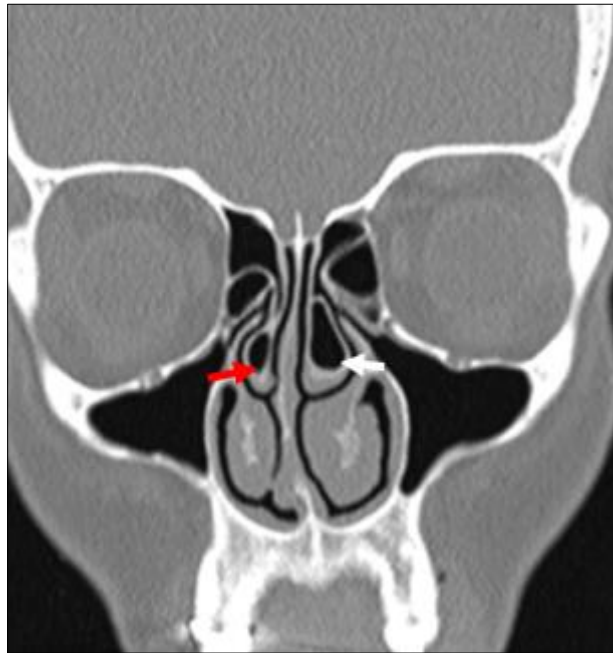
Coronal CT section showing left sided large concha bullosa (White arrow) and right medium concha bullosa (Red)
